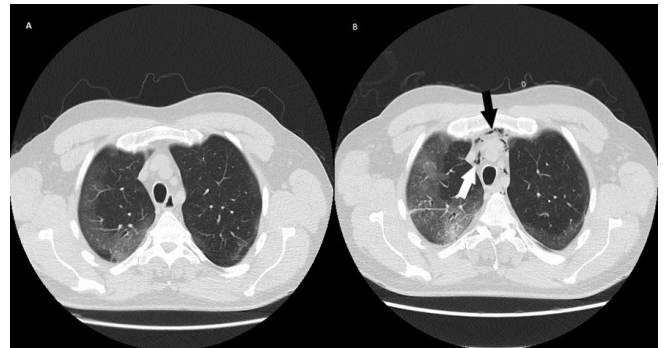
(A) CT scan of the neck region (on admission); (B) subcutaneous emphysema in the neck (arrow).
